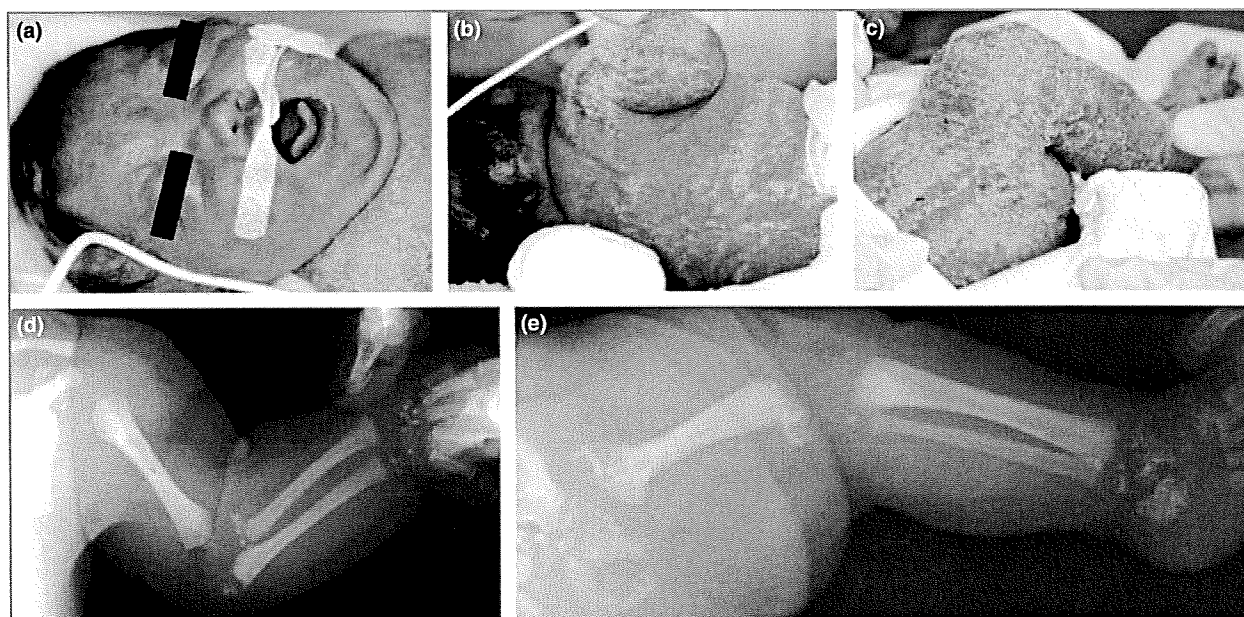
Clinical and X-ray appearance of the patient. (a) Frontal bossing and flat nasal bridge were seen on the face. (b) Circumscribed alopecia was noted on the scalp. (b, c) Linear and whorled hyperkeratosis was seen on a background of erythrodermic skin on the back (b) and over the thigh (c). (d, e) X-ray showed punctate calcification in the epiphyseal growth plate of the bones of the right arm (d) and in the right leg and hip (e).
